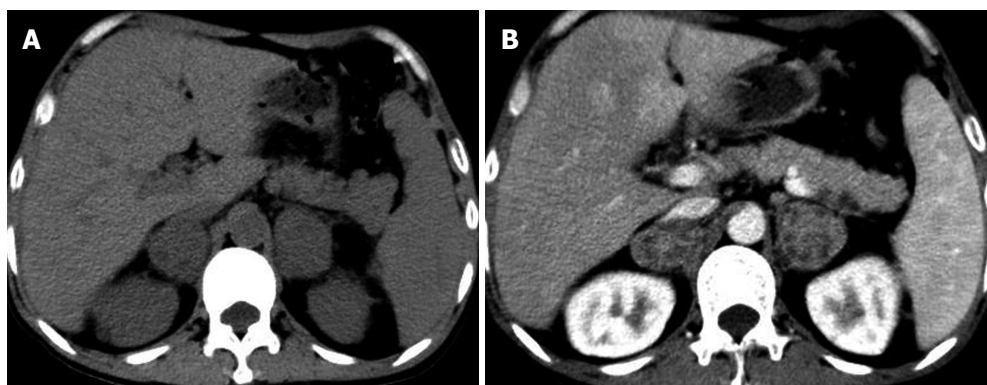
A 53-year-old man who has fatigue, pigmentation of skin and loss weight in last five months with primary adrenal insufficiency due to adrenal tuberculosis. The unenhanced (A) and contrast-enhanced (B) CT scans reveal the mass-like enlargement of the bilateral adrenals with multifocal peripheral enhancement. CT: Computed tomography.
